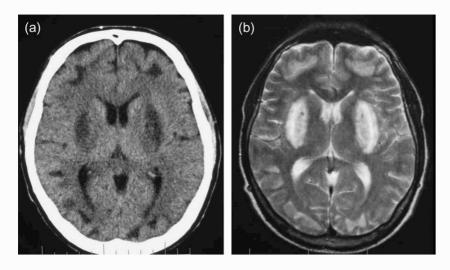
(a) Non-contrast CT head at the level of the lentiform nuclei shows low attenuation in the putamina and subcortical white matter consistent with infarction and oedema. (b) Long echo time, long repetition time MRI at the level of the lentiform nuclei shows extensive putaminal and predominant frontal and occipital lobe white matter high signal abnormalities due to oedema and necrosis from toxic brain injury.
